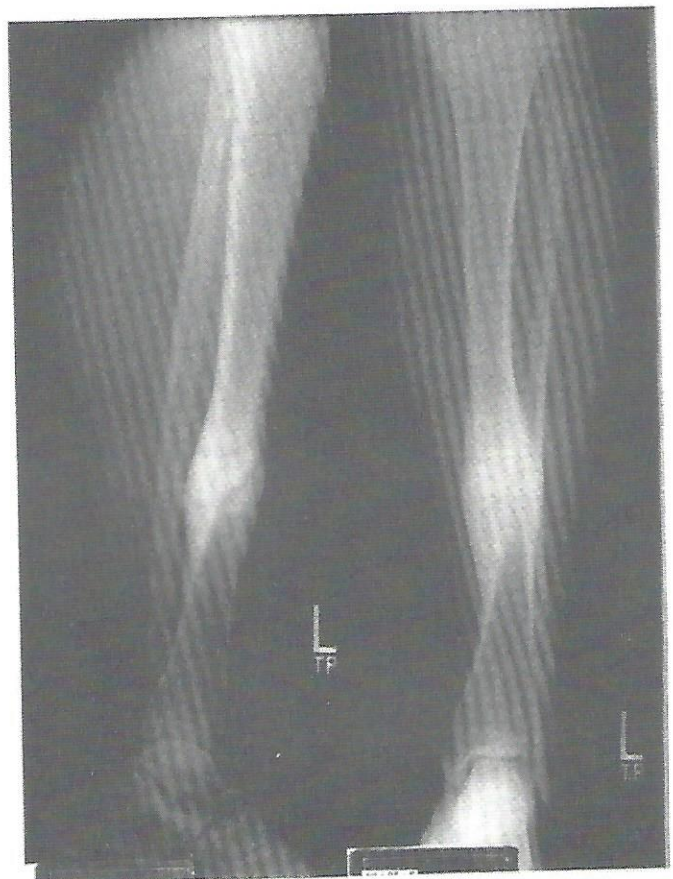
X-ray taken after seven months of PEMF treatment reveals obliteration of fracture gap with dense trabecular bridging and solid bony union through periosteal and endosteal callus.
